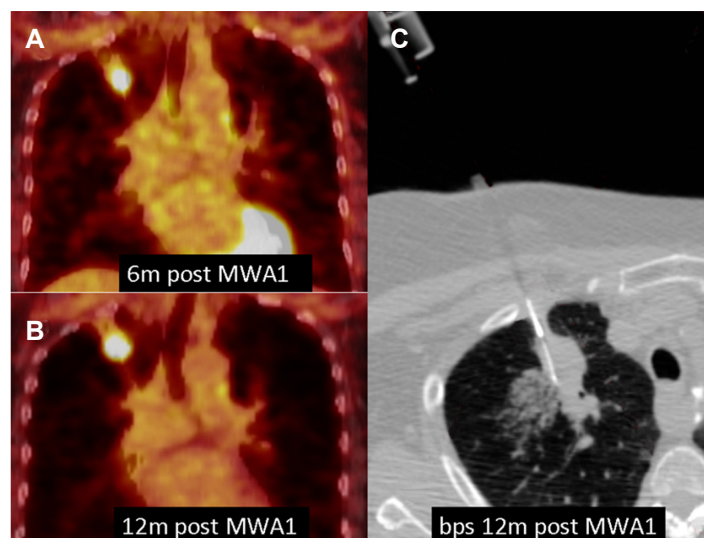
57-year-old female with right upper lobe SCC. A, B: Coronal FDG-PET/CT scans 6 months and 12 months post microwave ablation showing residual FDG avidity increasing; C: CT guided core biopsy demonstrated local recurrence of SCC. CT guided core biopsy demonstrated local recurrence of SCC. SCC: squamous cell carcinoma
